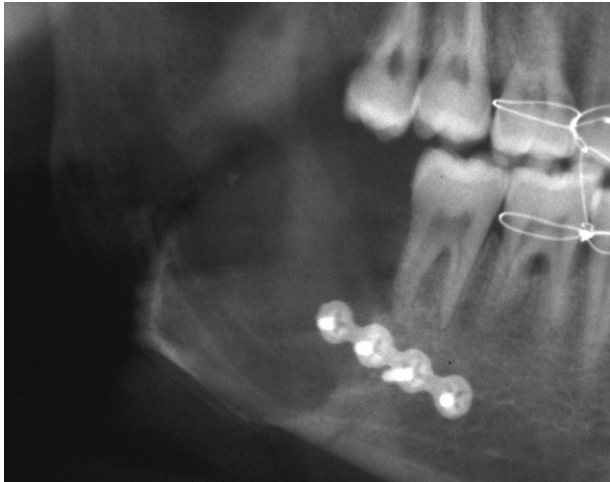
Postoperative panoramic x-ray view demonstrating reduction of the SSO fragments with AO miniplate and intermaxillary Ivy loops.
